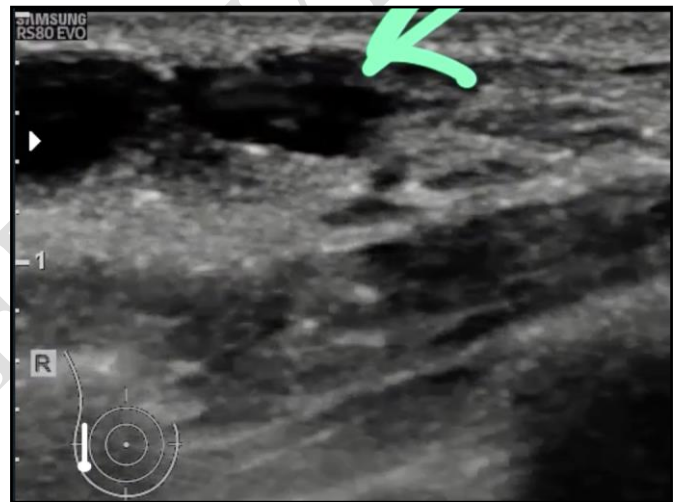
Ultrasound showing structure with dancing motility in a hypoechoic background.
